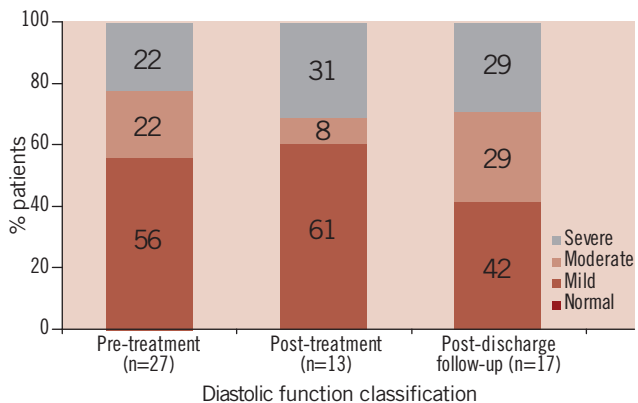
Classification of diastolic function during serial echocardiographic evaluation (n=number of patient echocardiograms with sufficient information for assessment of diastolic function).
